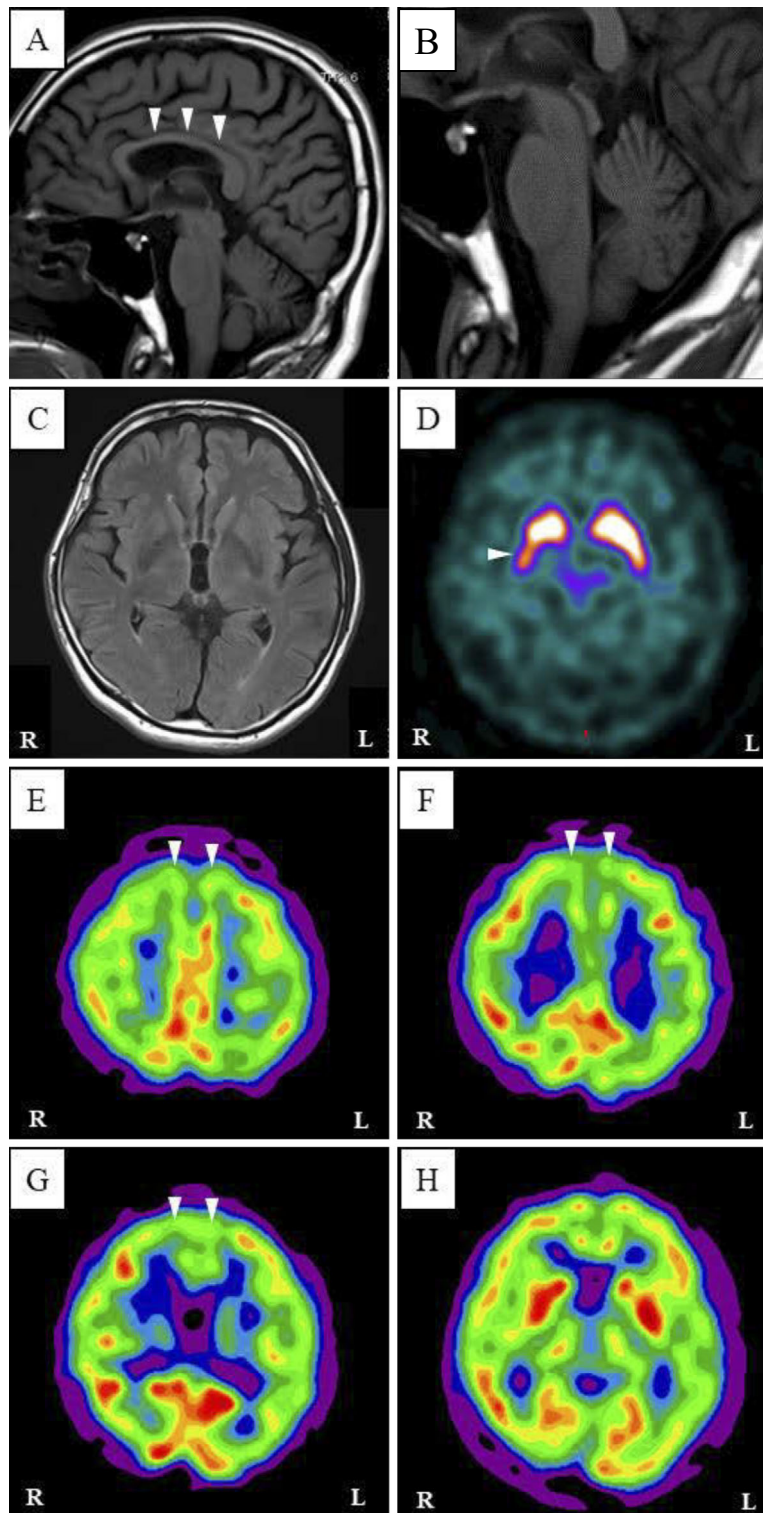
(A-C) Brain MRI showing a thin corpus callosum (A, arrowheads), but no significant lesions in the brainstem or bilateral basal ganglia (B and C). (D) A DAT scan showing a decreased accumulation in the right dorsal putamen (arrowhead). (E-H) ^{99m}Tc -ECD SPECT showing hypoperfusion in the bilateral frontal lobes (arrowheads).
